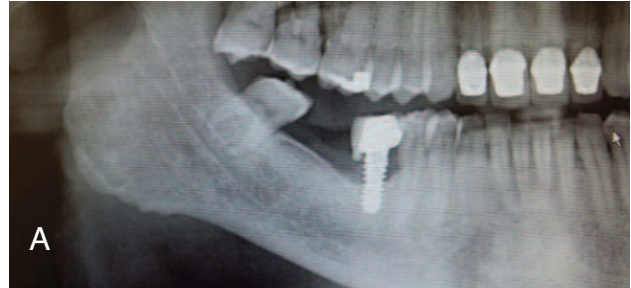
Clinical case 6 A, preoperative radiographic image in which it was decided to remove the implant in zone 46 in order to do a subsequent reconstruction with an autologous graft that would allow for the residual bone defect to be overcome. B, radiological image in which the autologous bone graft is seen. C, postoperative radiological image at one year of follow-up.
